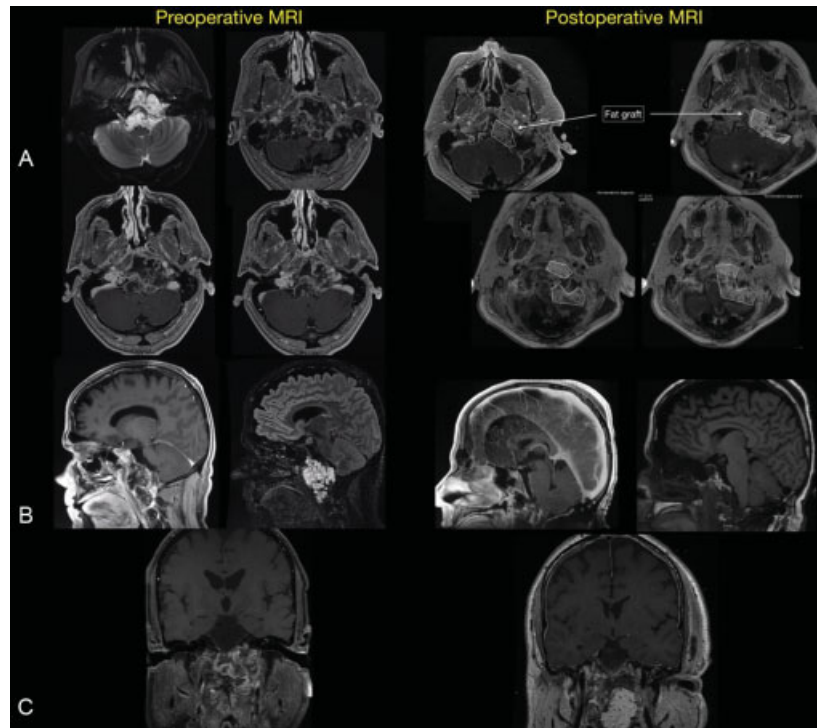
Preoperative MRI in (A) axial, (B) sagittal, and (C) coronal planes shows a heterogeneously enhancing expansile invasive mass lesion centered within the clivus and involving the C1, the occipitocervical junction, the retropharynx, and the hypoglossal canal and postoperative MRI in (A) axial, (B) sagittal, and (C) coronal planes shows a gross total resection of the tumor and the fat graft in the resection cavity without recurrence. MRI, magnetic resonance imaging.
